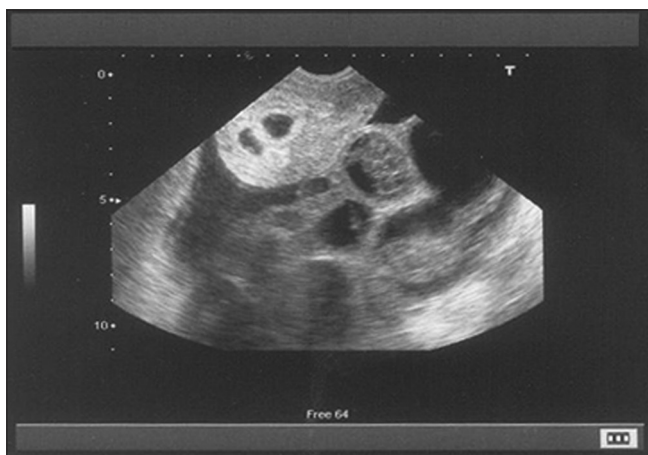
Ultrasound image showing twin gestation with enlarged ovaries and fluid in pouch of douglas
